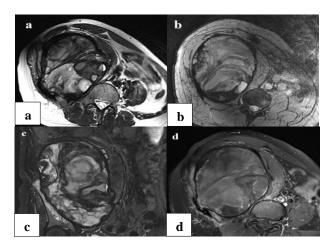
Shows a) axial T2 weighted MRI image shows a heterogeneous predominantly hypointense lesion with fluid-fluid level within centered in the right iliopsoas muscle causing erosions in the right iliac bone; b) axial medic sequence shows peripheral blooming, raising the suspicion for a hematoma; c) coronal TIRM sequence shows a heterogeneous predominantly hypointense lesion with few hyperintense areas within, underlying right iliac bone shows signal abnormalities; and d) axial T1 weighted post contrast image shows minimal peripheral enhancement and enhancement of the internal septae.
